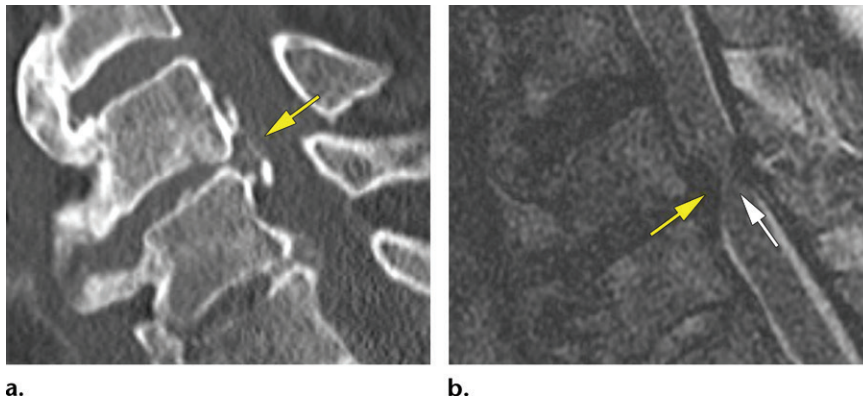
Central cord syndrome in a 77-year-old man with DISH who fell down stairs and presented with sensory deficit and bilateral arm and leg weakness. (a) Sagittal CT image of the cervical spine shows an area of discontinuity of the C4-C5 posterior osteophytes (arrow) but was interpreted as negative for fracture. MRI was performed owing to neurologic deficits. (b) Sagittal T2-weighted MR image shows a large C4-5 disk extrusion (yellow arrow), causing cord compression and edema (white arrow). These imaging findings support the clinical diagnosis of central cord syndrome.
